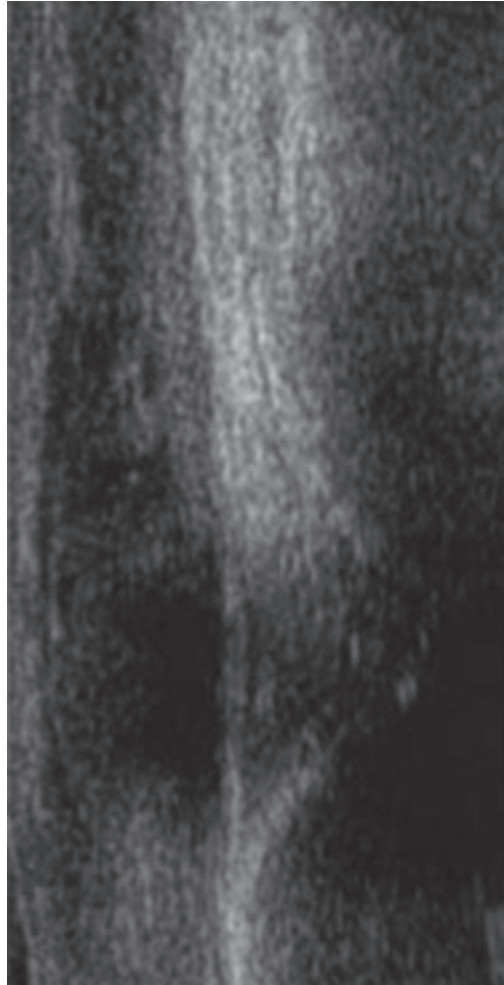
Ultrasound demonstrating hypoechoic changes within the tibialis anterior tendon which are consistent with a rupture
